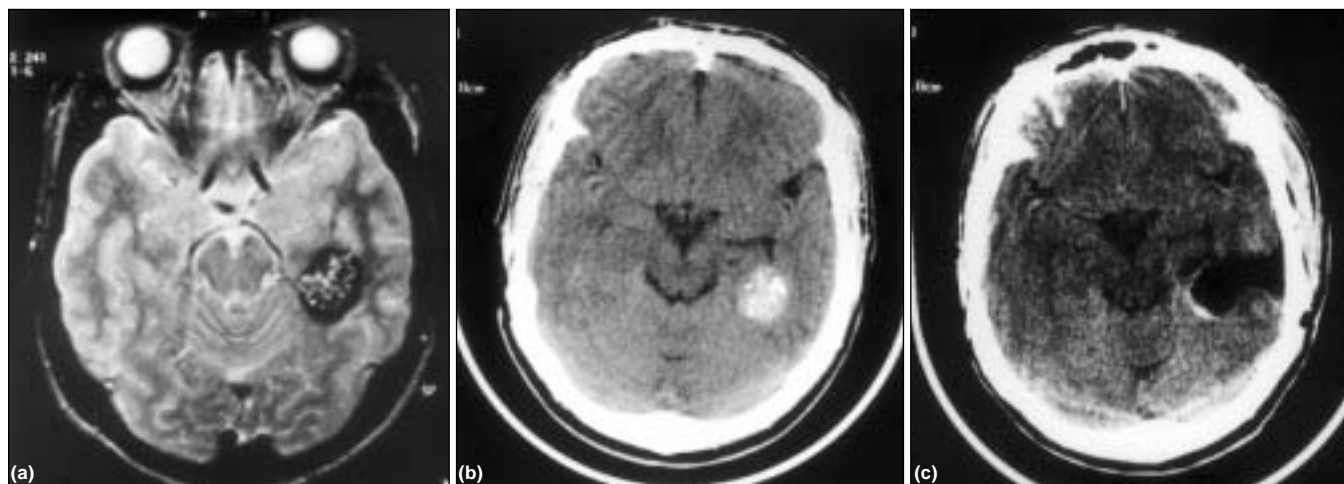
(a) Preoperative axial MRI of a calcified cavernous angioma is located left temporal lobe (b) Preoperative CT of the same patient (c) Postoperative CT of the same patient(pathologic diagnosis is same)
